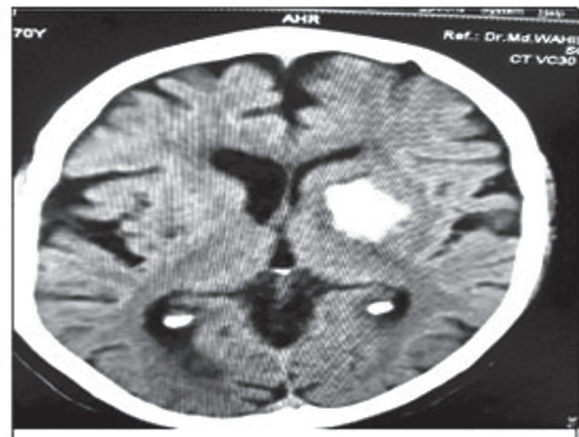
CT scan of brain. Left basal ganglion acute haemorrhage in left MCA territory.
